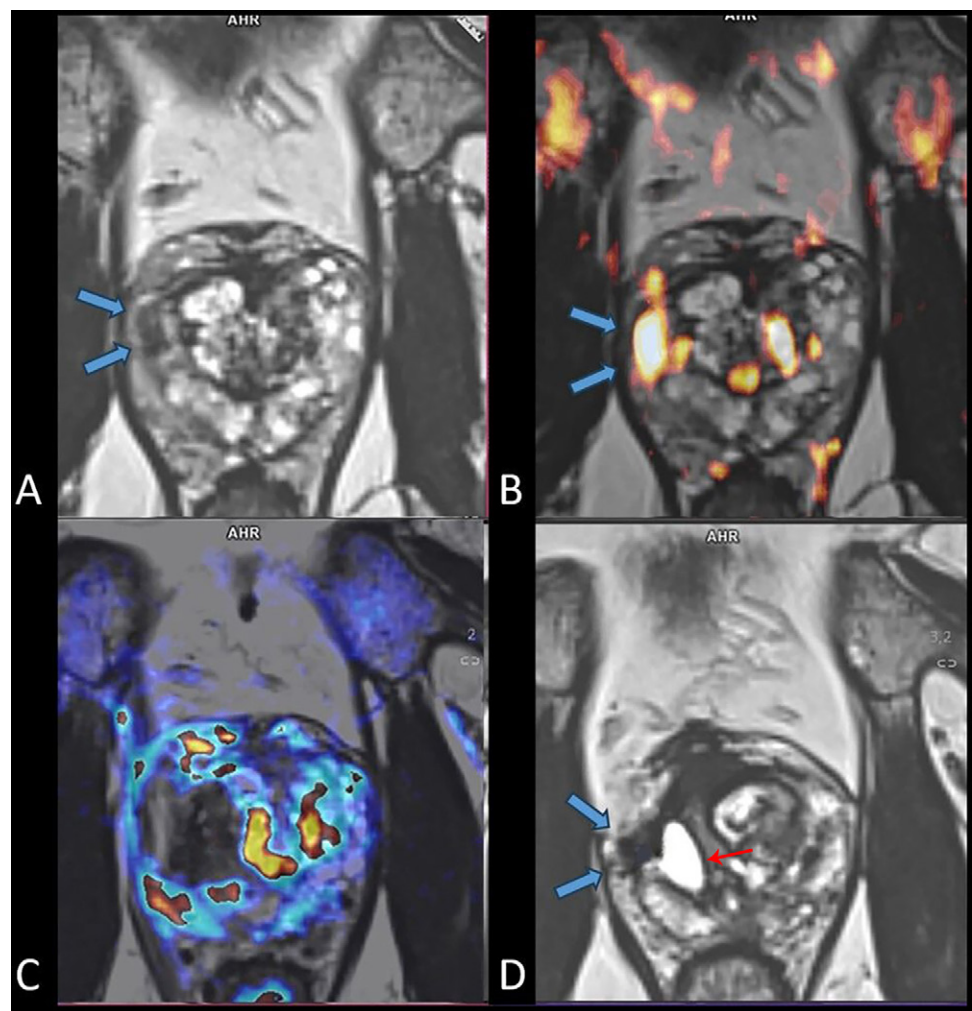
T2-weighted three-dimensional MRI scans in a 62-year-old male participant (initial prostate-specific antigen level, 7.6 ng/mL) with a Prostate Imaging Reporting and Data System (PI-RADS) 4 lesion (blue arrows) in the anterior sector of the right peripheral zone (maximum tumor length, 11 mm). A Gleason score 3 + 4 lesion was diagnosed with targeted biopsies, with 20% grade 4 tumor and a cribriform component of 0%. (A, B) T2-weighted transverse images show a PI-RADS 4 lesion in the anterior sector of the right peripheral zone (arrows). (C) T2-weighted transverse image superimposed with contrast-enhanced image acquired 4 days after focal ablation shows the treated area, which is avascular. The absence of vascularization extends beyond the outer edge of the prostate, reflecting the transcapsular extension of thermal necrosis. (D) T2-weighted transverse image acquired 12 months after focal ablation shows an avascular scar with a low T2-weighted signal intensity in the treated lesion (blue arrows). Medially, a fluid cavity (red arrow) secondary to thermal necrosis is visible.
